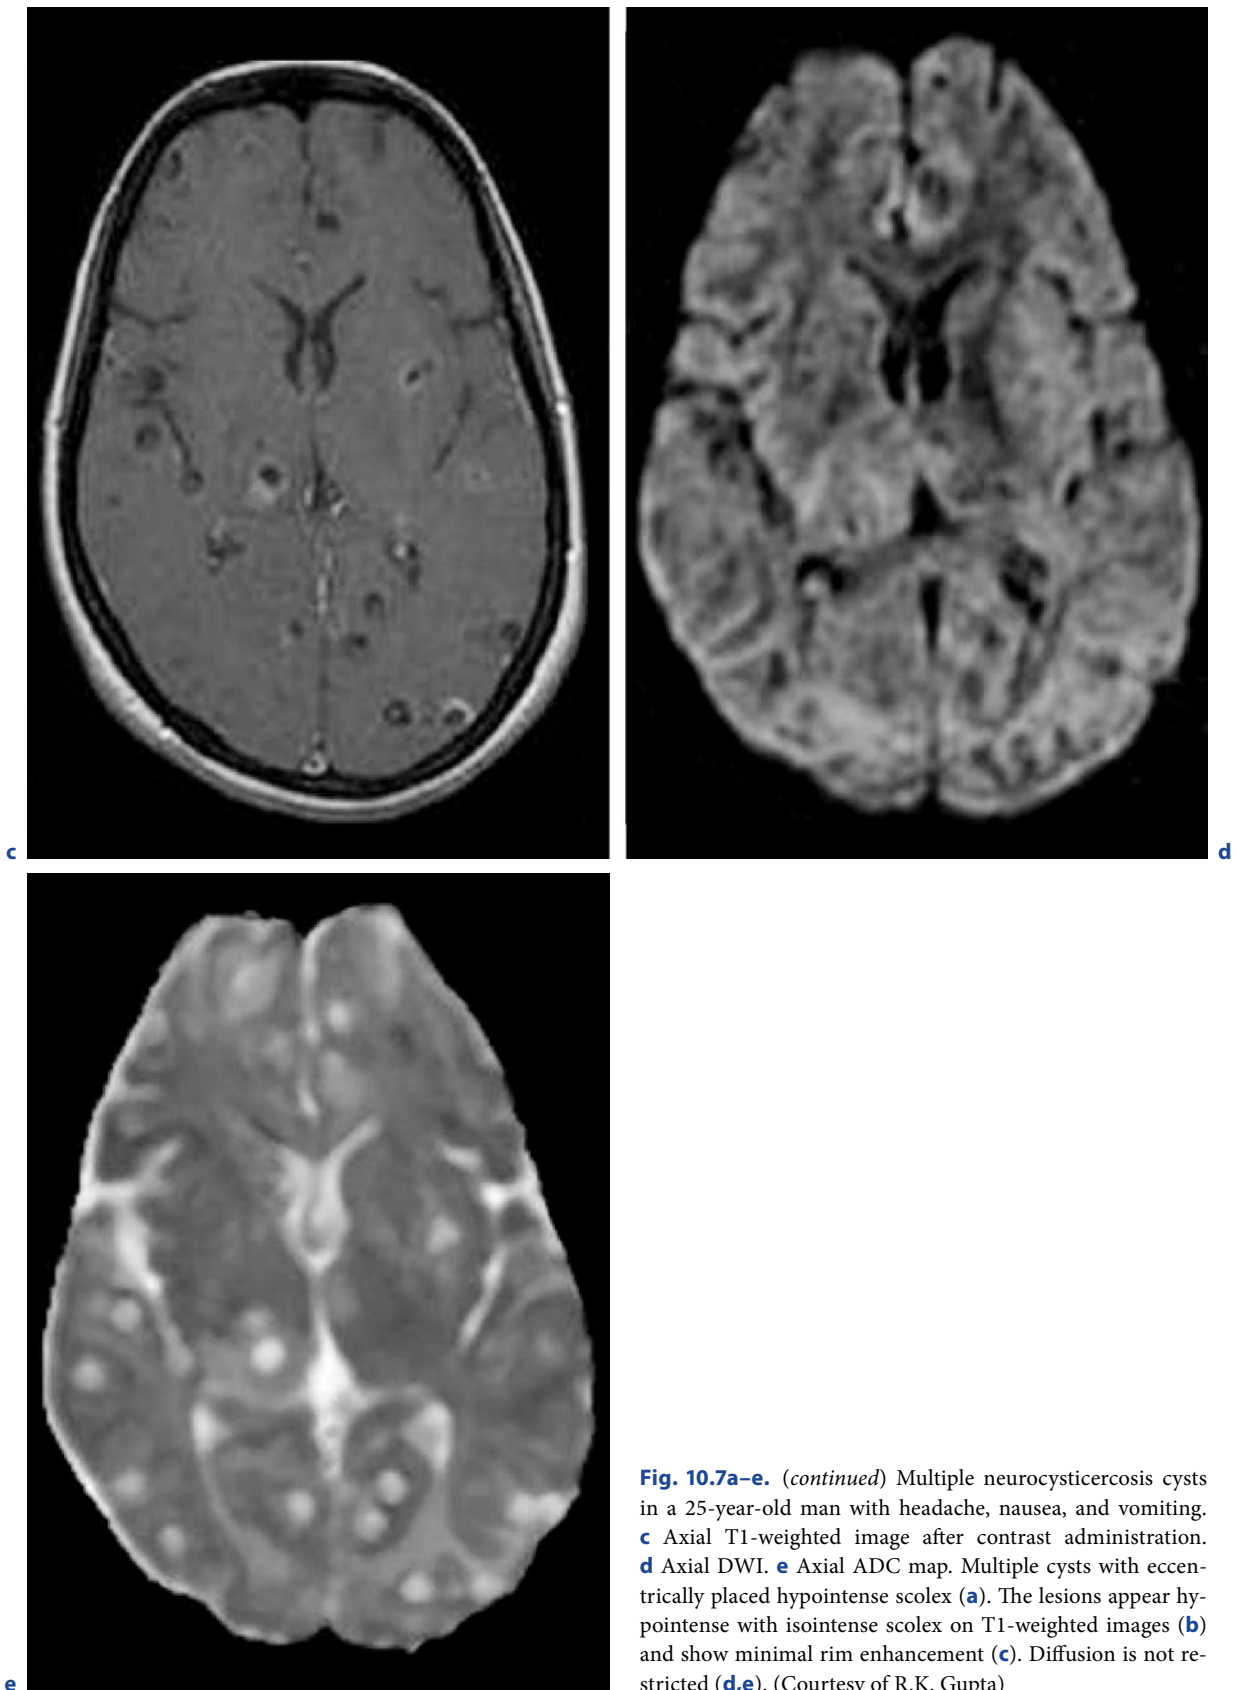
(continued) Multiple neurocysticercosis cysts in a 25-year-old man with headache, nausea, and vomiting. c Axial T1-weighted image after contrast administration. d Axial DWI. e Axial ADC map. Multiple cysts with eccentrically placed hypointense scolex (a). The lesions appear hypointense with isointense scolex on T1-weighted images (b) and show minimal rim enhancement (c). Diffusion is not restricted (d,e). (Courtesy of R.K. Gupta)
